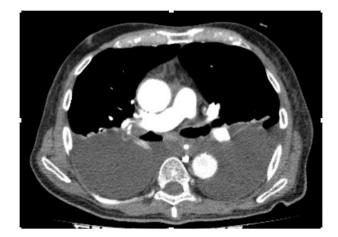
Thoracic CT scan taken 3 days after the occurrence of chest pain. Note the bilateral pleural effusion and mediastinal hematoma.
